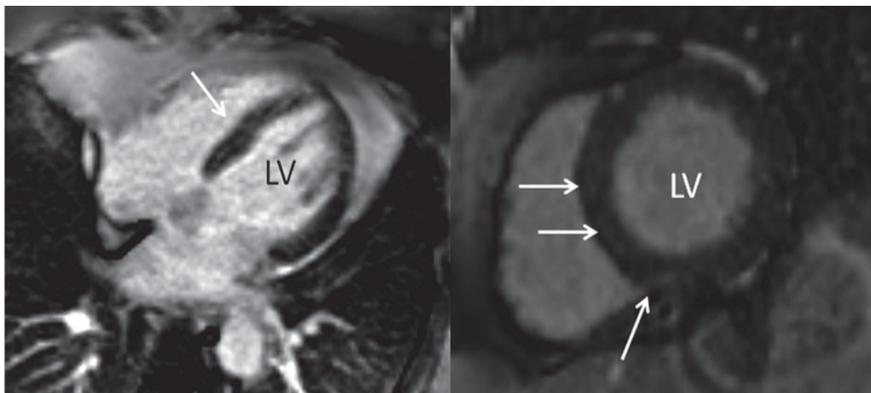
Cardiac magnetic resonance images of 64-year old patient with chronic and active rheumatoid arthritis. Four-chamber (A) and short-axis views (B) of the heart show linear, late gadolinium enhancement of the basal interventricular septum (arrow) and patchy enhancement of right ventricular insertion (arrow head), LV: left ventricle.
